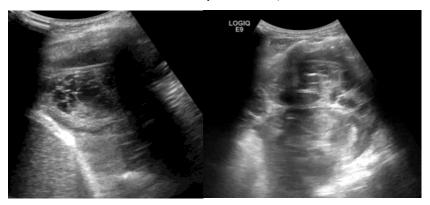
Thoracic ultrasound image confirming the presence of multiple daughter cysts within the pleural space, supporting the diagnosis of pleural hydatid disease.
